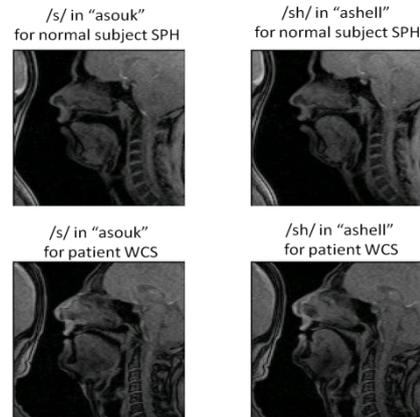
The midsagittal MR images of /s/ (left) and /sh/ (right) production by the normal subject SPH (upper) and the patient WCS (bottom) after surgery
